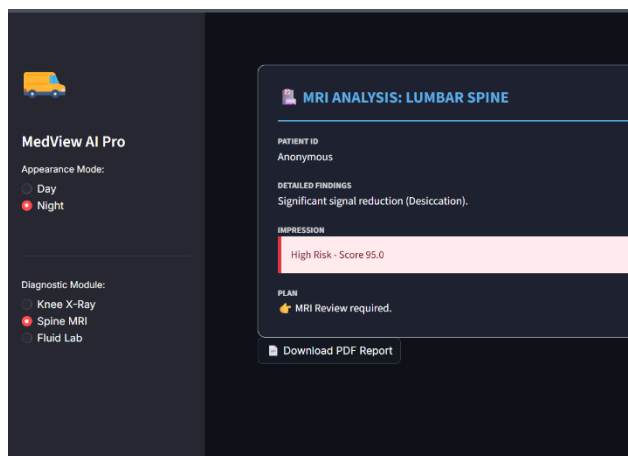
Spine MRI degeneration analysis output.
